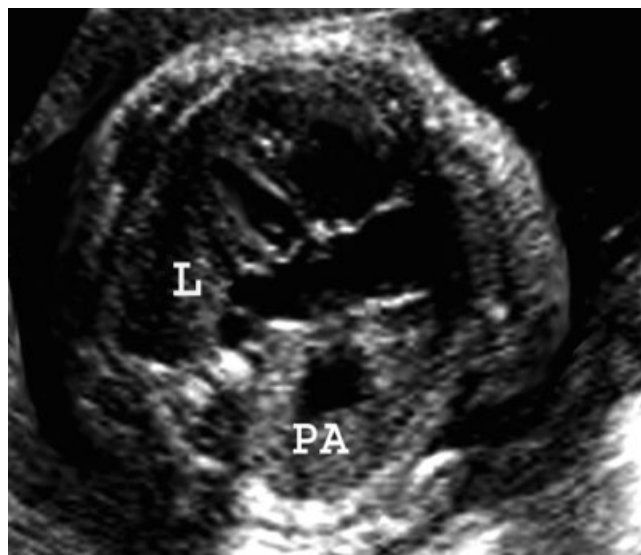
Ultrasound image of a case in which the cardiothoracic ratio was increased and the pulmonary artery (PA) was so dilated it was visible in the four-chamber view. L, lung.
